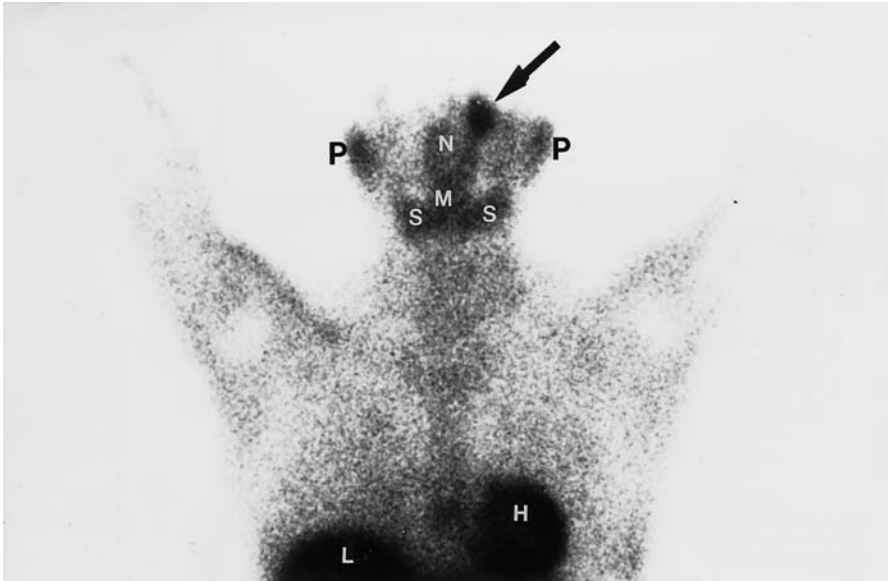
^{99m}Tc -MIBI anterior planar image of the head, neck, and chest after total thyroidectomy with surgical absence of thyroid bed activity and normal uptake in the parotid glands (*P*), nasopharynx (*N*), mouth (*M*), submandibular glands (*S*), heart (*H*), and liver (*L*). The patient has a solitary orbital metastasis of Hürthle cell thyroid cancer, which was negative on ^{131}I scintigraphy
